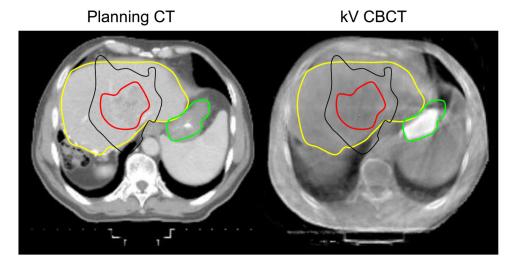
Planning CT (left) and kV CBCT (right) with the administration of oral contrast to aid in IGRT and avoidance of the stomach. The planning contours are overlaid for visualization: yellow=liver, red=GTV, black=isodose representing 31Gy in 6 fractions, green=stomach
